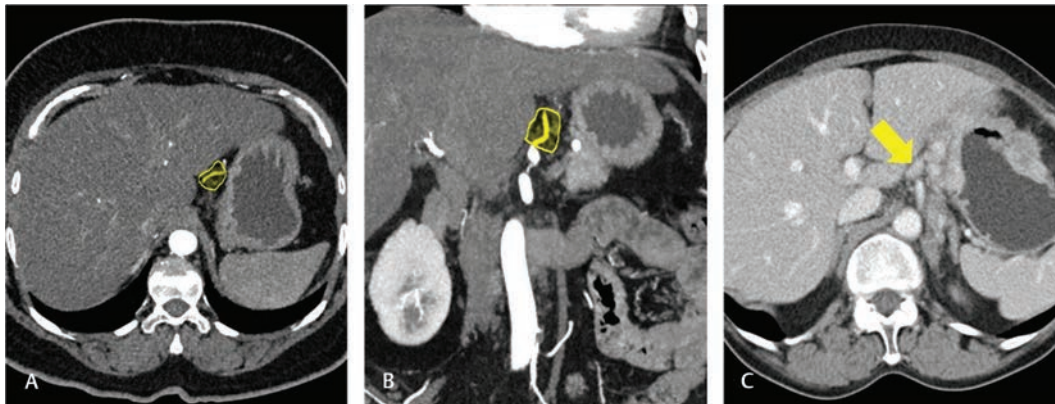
Station 7. Axial and coronal reformatted CT (A) and (B) in arterial phase showing origin and proximal left gastric artery along which lie station 7 nodes (yellow area in A and B). Axial CT in venous phase show multiple left gastric nodes (arrow in C). CT, computed tomography.
